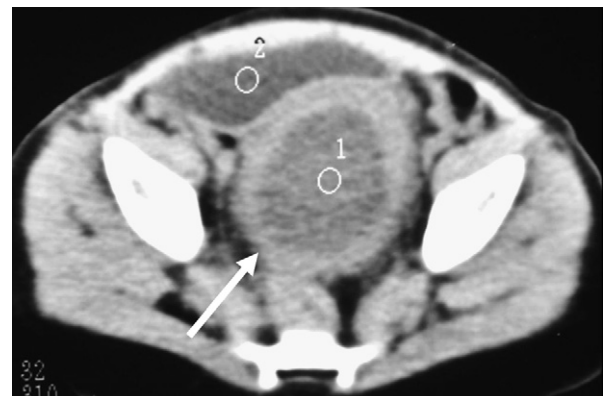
CT scan of the pelvic region. Arrow showing augmentation of the prostate with the Müllerian cyst at its center.
